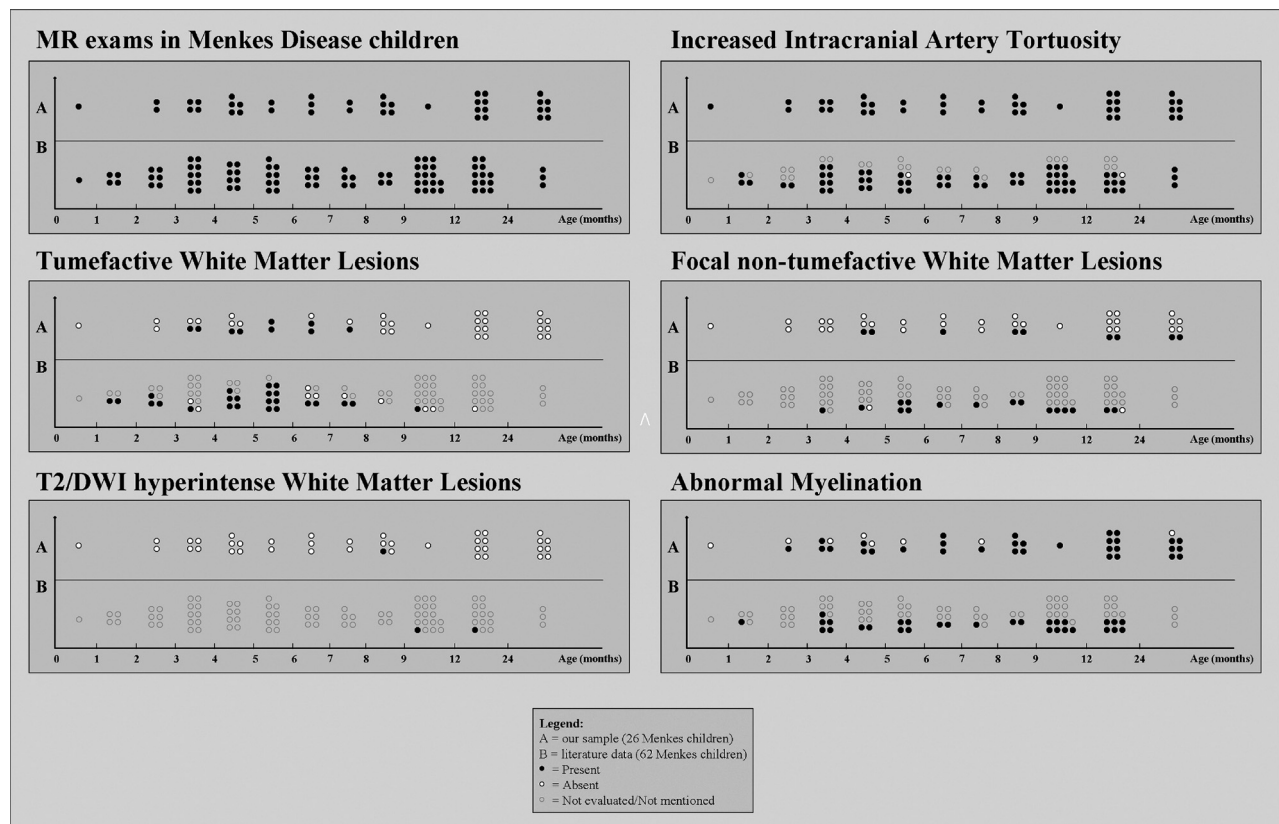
MR imaging findings in Menkes disease according to age at examination: A, Our sample (26 children, 40 examinations). B, Literature review (62 children, 86 examinations).
